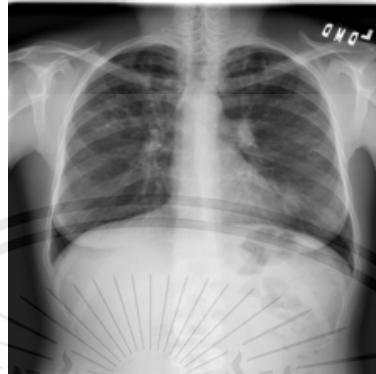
Example of Fibrosis chest X-Ray image (Wang, Yifan Peng, Le Lu, Zhiyong Lu, & Ronald M. Summers, 2018)
